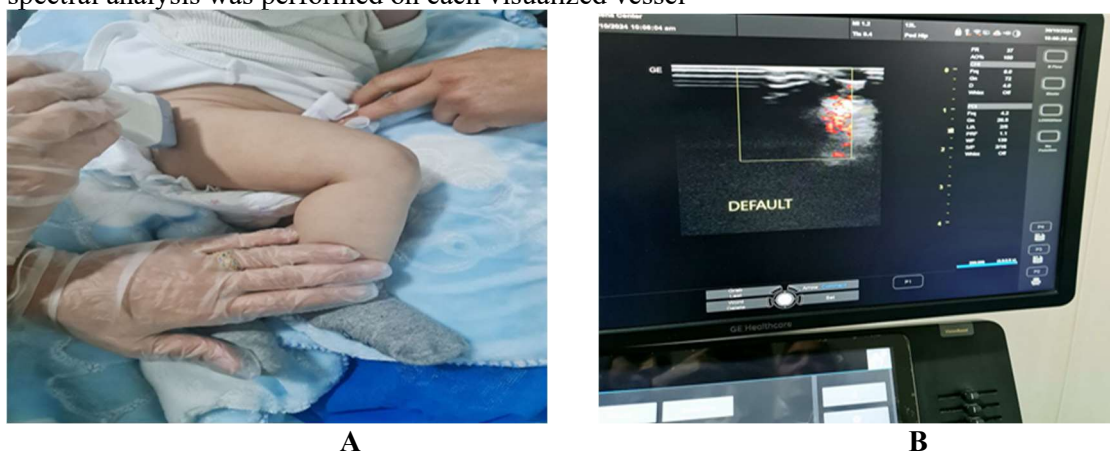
A: Coronal lateral neutral plan, B: PD ultrasound parameters at Helena specialized center
